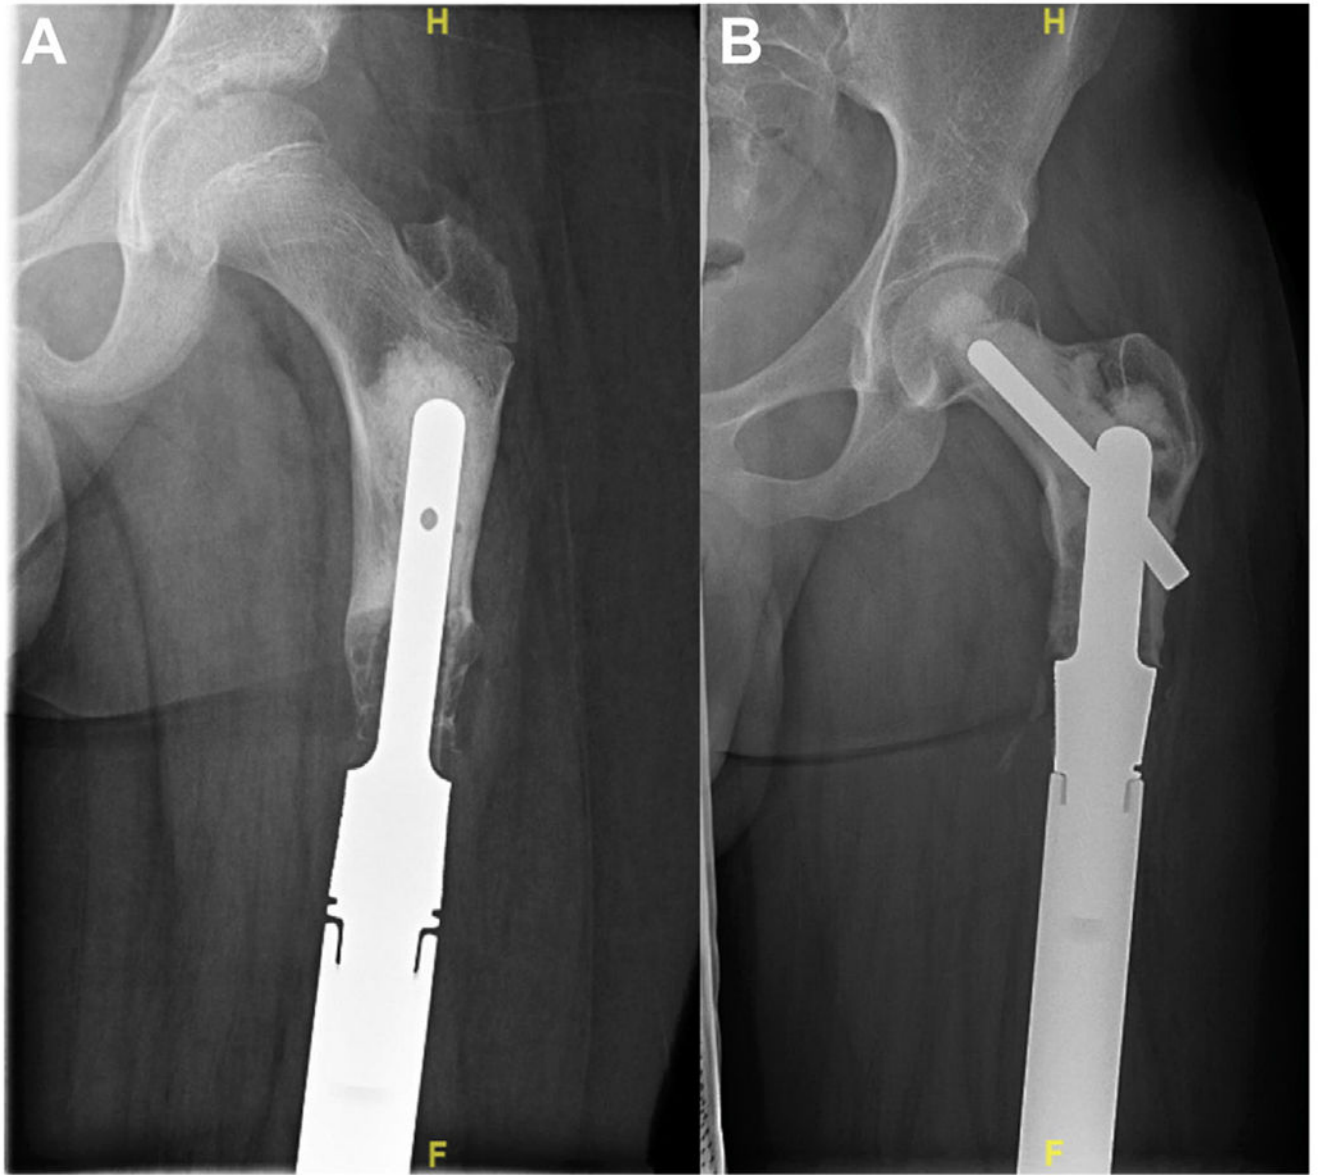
(A, B): Radiographs of the proximal femur 2.8 years postoperatively in a 9-year-old male with osteosarcoma demonstrating a metaphyseal stem tip that went on to aseptic loosening (A). He was treated with implant revision using custom cross pin fixation in the femoral neck, which remains stable without evidence of loosening 9 years postoperatively (B).
